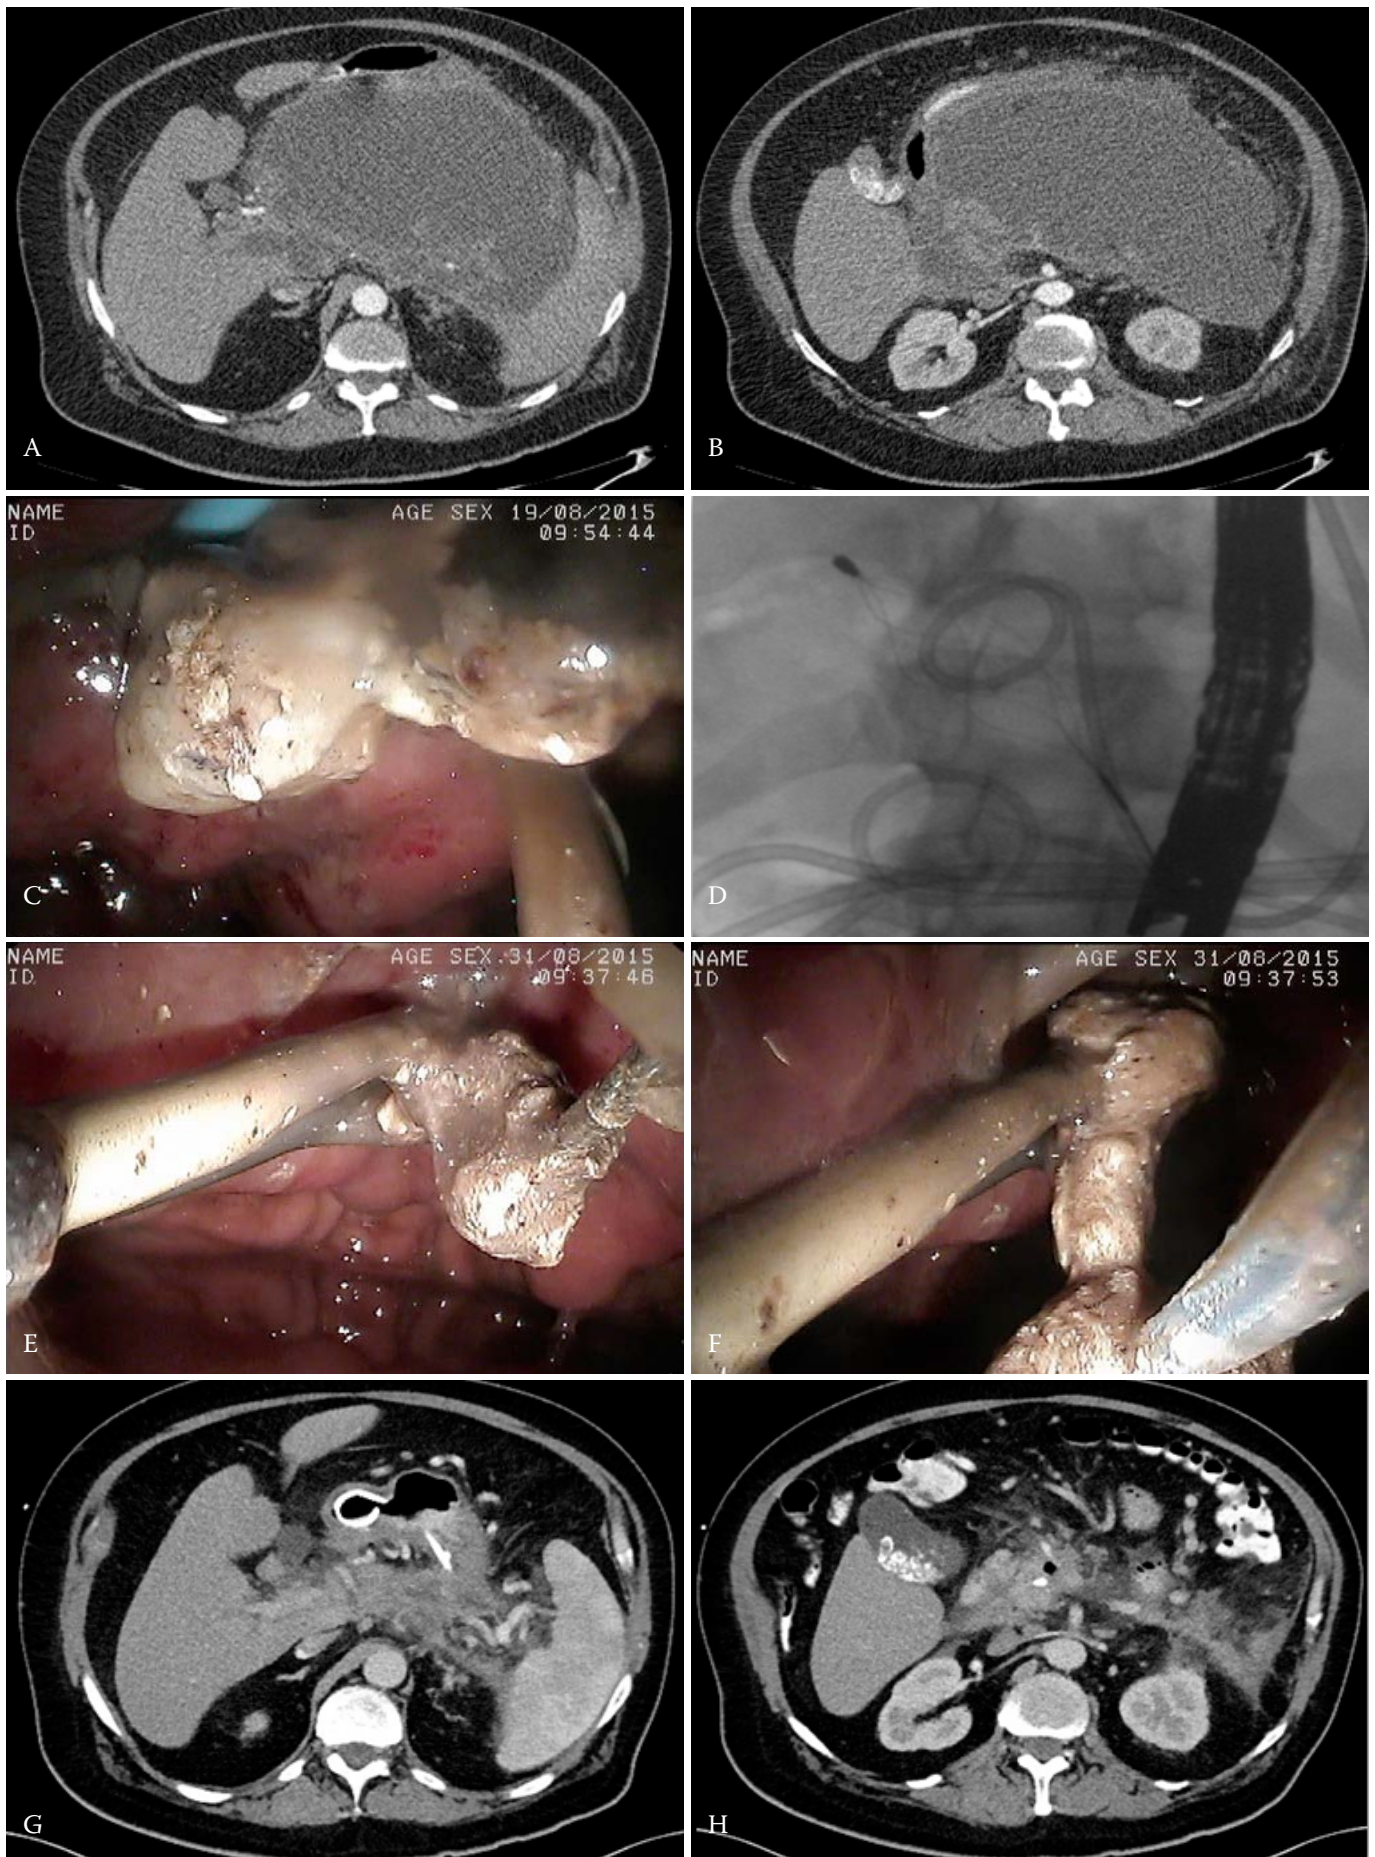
A patient with walled-off pancreatic necrosis visible in contrast-enhanced computed tomography of the abdomen (A, B). Endoscopic necrosectomy under fluoroscopic guidance was performed during transmural drainage (C, D). Numerous fragments of necrotic tissues were removed from the necrotic cavity during endoscopic necrosectomy (E, F). Abdominal contrast-enhanced computed tomography performed after the end of endoscopic treatment revealed complete regression of WOPN (G, H).
